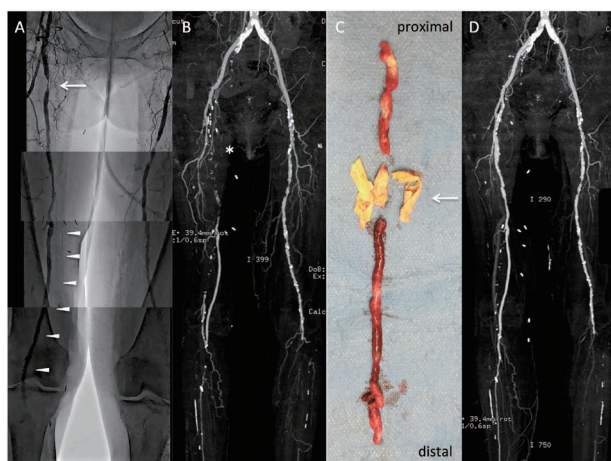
(A) Angiography of lower extremity 3 months ago revealed short segment stenosis in the proximal SFA (arrow), and a patent vein graft from the distal SFA to the POPA (arrowheads). The distal POPA, anterior tibial artery, and posterior tibial artery were occluded but proximal site of the peroneal artery was patent-filled by collateral perfusion. (B) Computed tomography angiography showed occlusion of SFA from its orifice (*). (C) Gross appearance of extracted atherosclerotic lesion (arrow) and occluded bidirectional thrombi. (D) One-week follow-up CTA revealed good flow of 'one straight line.'
